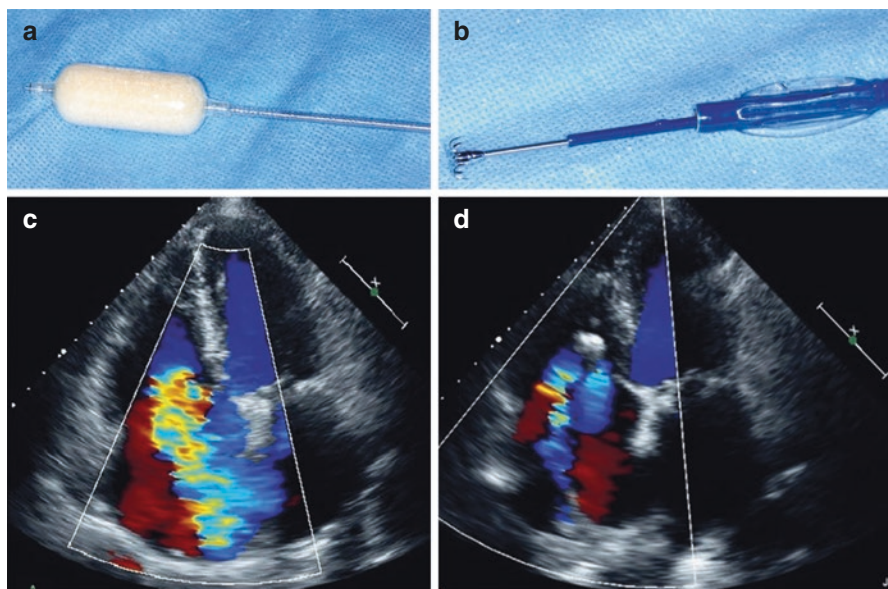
The FORMA Repair System. (a) Spacer. (b) Steerable delivery catheter and anchoring system. Apical 4-chamber-view of TEE of the same patient before (c) and after (d) device implantation. Reprinted with permission from Campelo-Parada et al. [34]. EROA $\frac{1}{4}$ effective regurgitant orifice area; TEE $\frac{1}{4}$ transesophageal echocardiography
